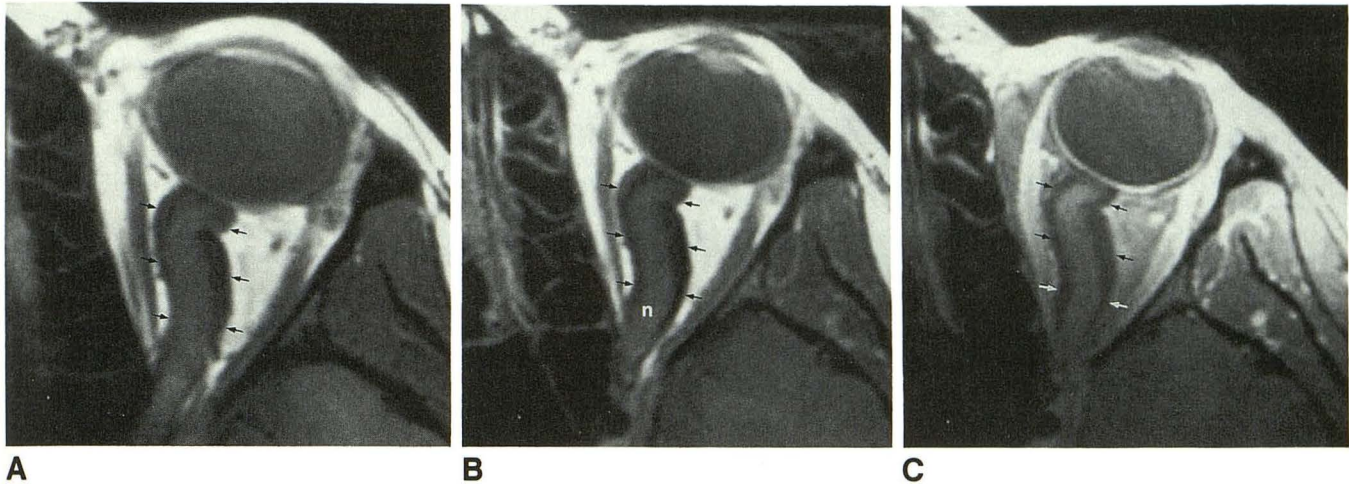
A–C, Axial T1-weighted spin-echo MR images of an optic nerve glioma before IV injection of gadopentetate dimeglumine (A), after contrast administration (B), and with fat suppression after contrast administration (C). No appreciable enhancement of the optic nerve (n) or sheath (arrows) is observed in either B or C. Thickening of the nerve sheath is probably due to arachnoid hyperplasia.
